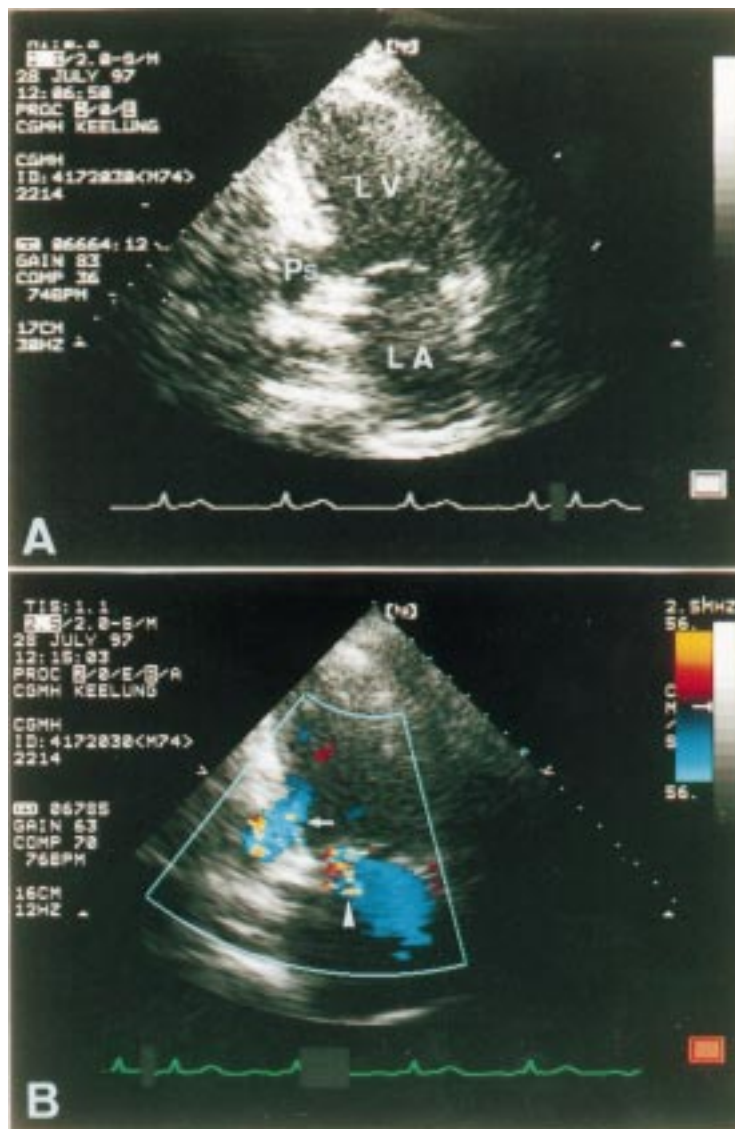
(A) Apical two chamber view of transthoracic cross sectional echocardiography six months after myocardial infarction, showing the pseudoaneurysm posterior to the left ventricle. (B) Colour Doppler study revealing a flow entering the pseudoaneurysm (arrow) and a mitral regurgitant jet (arrowhead). LA, left atrium; LV, left ventricle; Ps, pseudoaneurysm.
